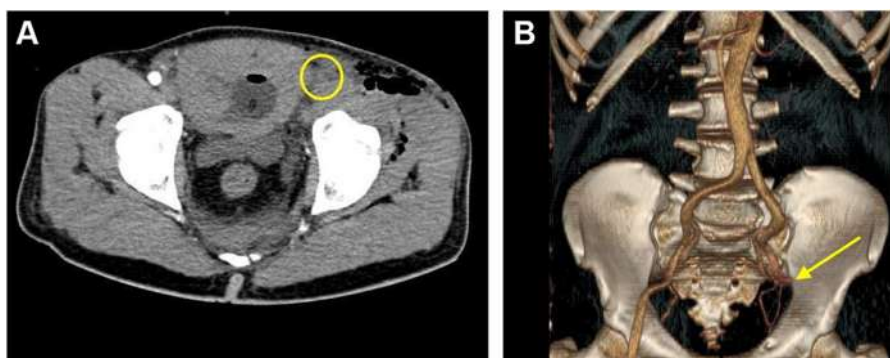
(A) Computed tomographic angiography showing filling defect in the left distal external iliac and left proximal common femoral artery (marked with yellow circle). (B) 3-dimensional reconstructed image showing complete cutoff of flow beyond external iliac (marked with a yellow arrow).
